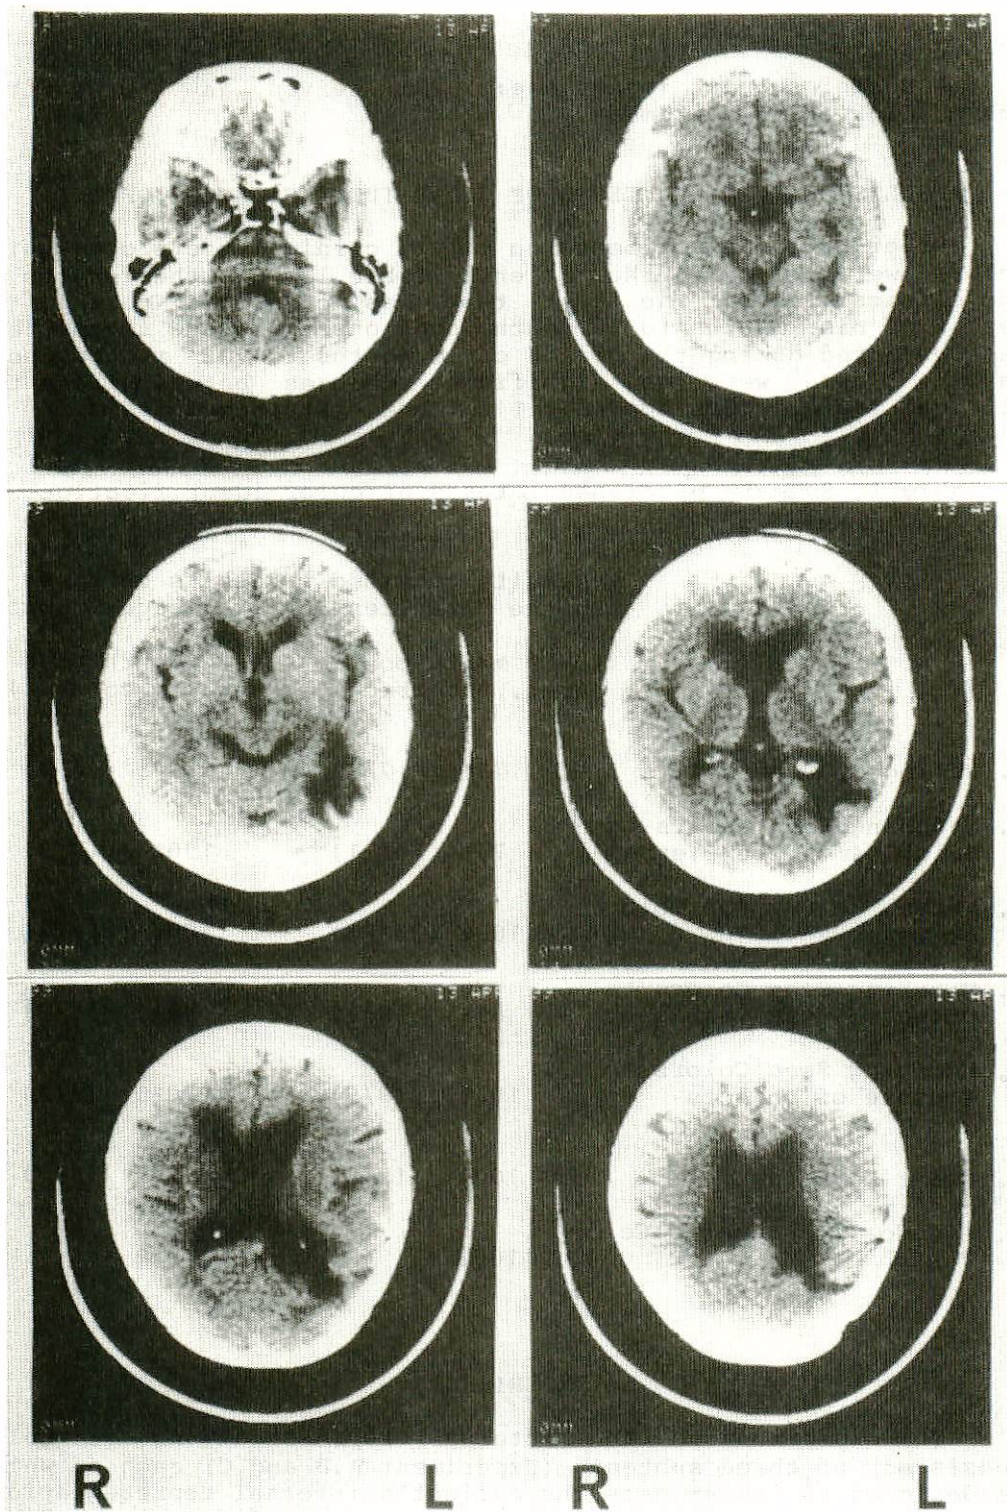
CT Scan of M.S.
